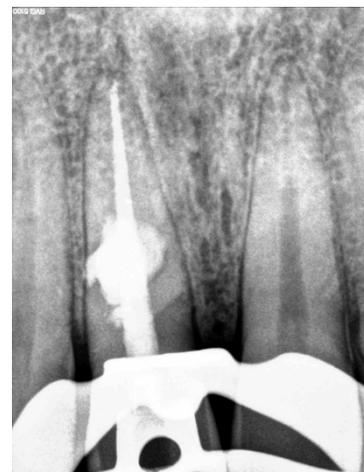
Radiograph showing obturation with thermoplasticized gutta-percha
